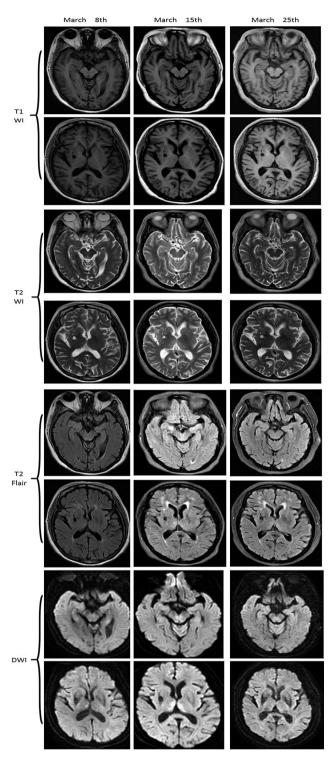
Brain MRI changes of the patient Brain MRI on March 8th did not show significant lesions on T1WI, T2WI, T2Flair and DWI. Brain MRI on March 15th showed hyper signal lesions in the midbrain aqueduct and bilateral thalamus on T2WI, DWI and T2flair. After treatment, brain MRI on March 25th showed smaller hyper signal lesions in the midbrain aqueduct and bilateral thalamus on T2WI, DWI and T2flair
